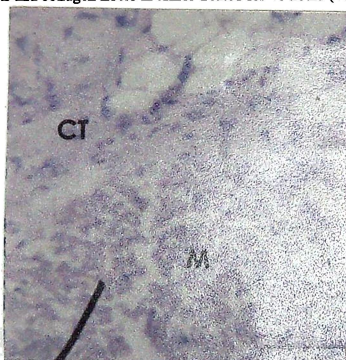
Damaged muscle tissue intermixed with necrotic debris (M) and surrounded by a thin fibroblast wall (CT) in tumor treated for 48 hours (400X).
